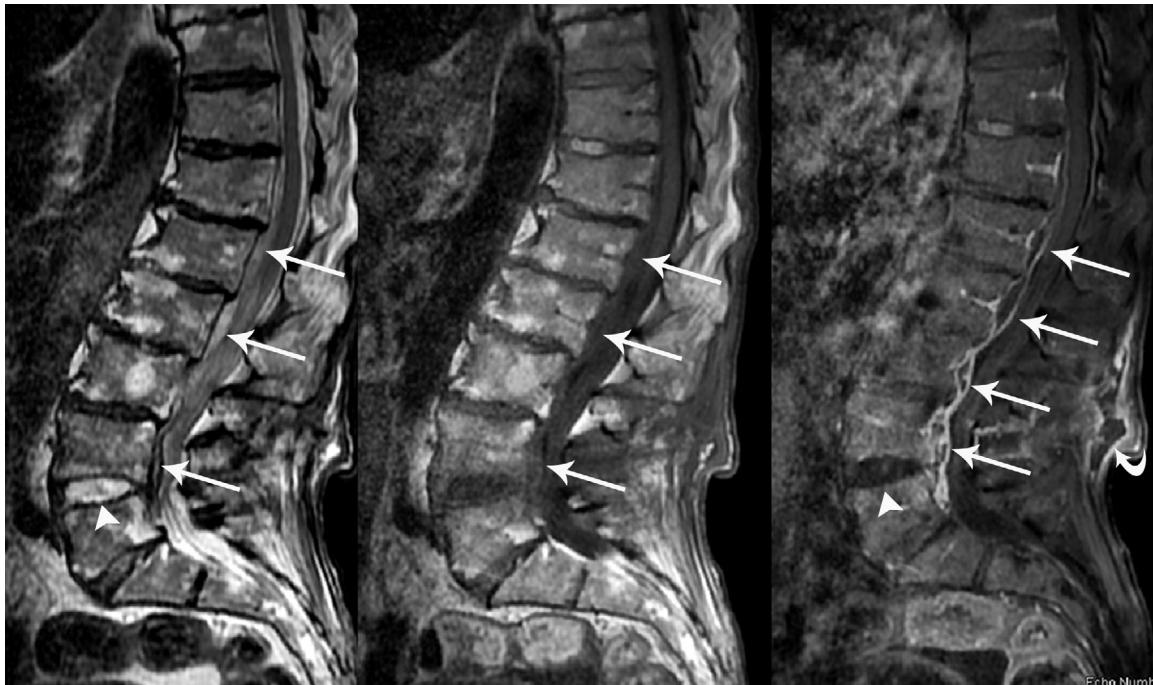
Lumbar sagittal MRI showed a lesion between the L1 and L5 vertebrae with low signal on T1-weighted image (Left), high signal on T2-weighted image (Middle), and peripheral enhancement on postcontrast image consistent with epidural empyema (arrows). There was T2 hyperintensity in the L4–L5 disc caused by discectomy (arrowhead in Left), but MRI findings of spondylodiscitis were not detected (arrowhead in Right). A small subcutaneous abscess was also found in the surgical site (curved arrow in Right).
